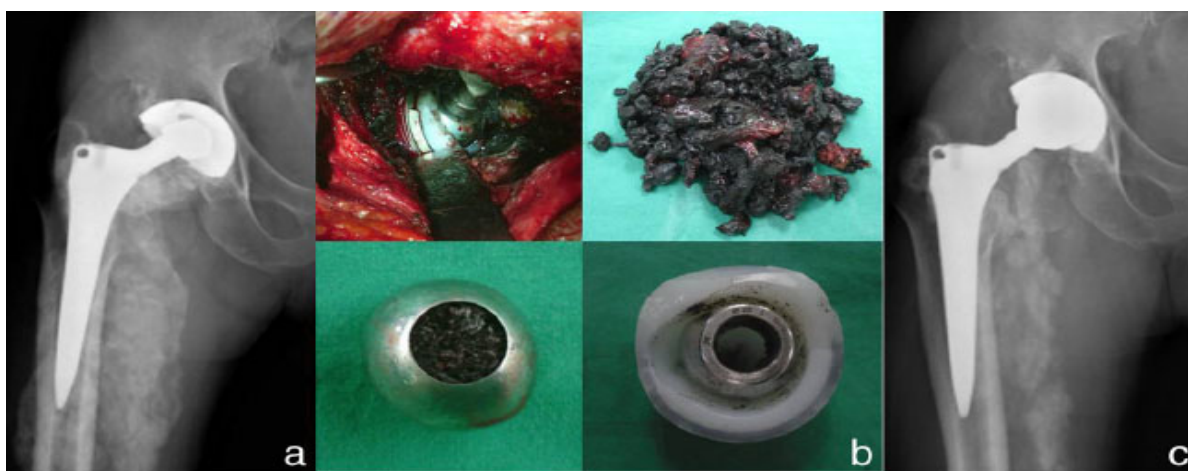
A 62-year-old male patient with right hip joint arthroplasty using MoP prosthesis a) radiograph shows liner wear and metallosis b) severe metallosis and osteolysis c) post corrective surgery radiograph including excision of mass, change in metasul liner and metal head after cementing^(59,8)
